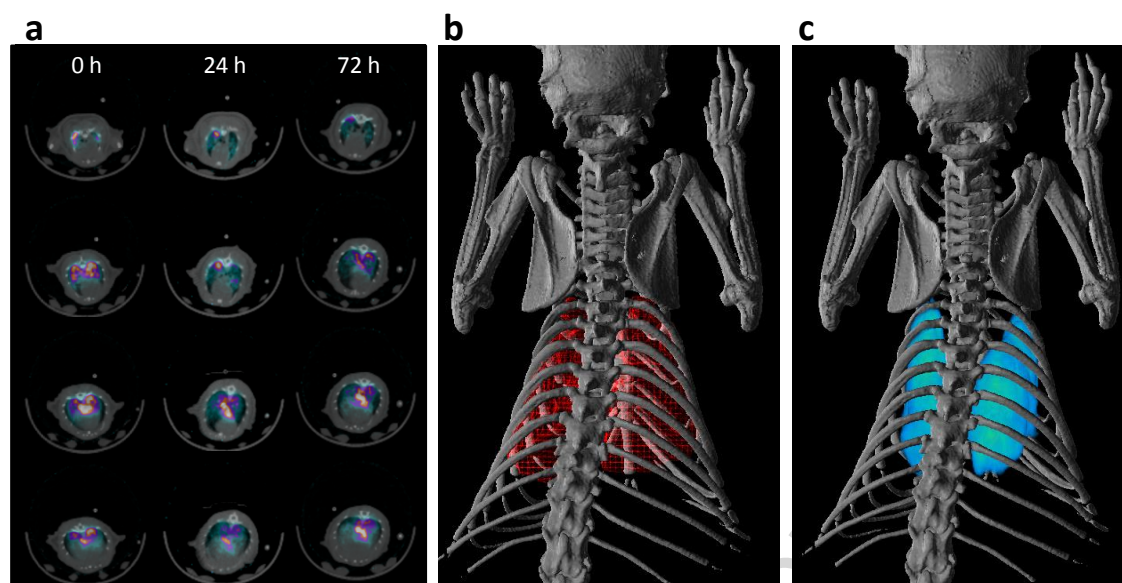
a) Representative axial slices of SPECT-CT images obtained at $t = 0$, 24 and 72 hours after administration of ^{67}Ga -labeled particles by intra-tracheal nebulization; SPECT images are co-registered with CT images for easy localization of the radioactivity; b) 3D CT images of the skeleton (grey) co-registered with surface-rendered 3D CT images of the lungs; c) 3D CT images of the skeleton (grey) co-registered with volume-rendered SPECT images of the lungs (green tones).
